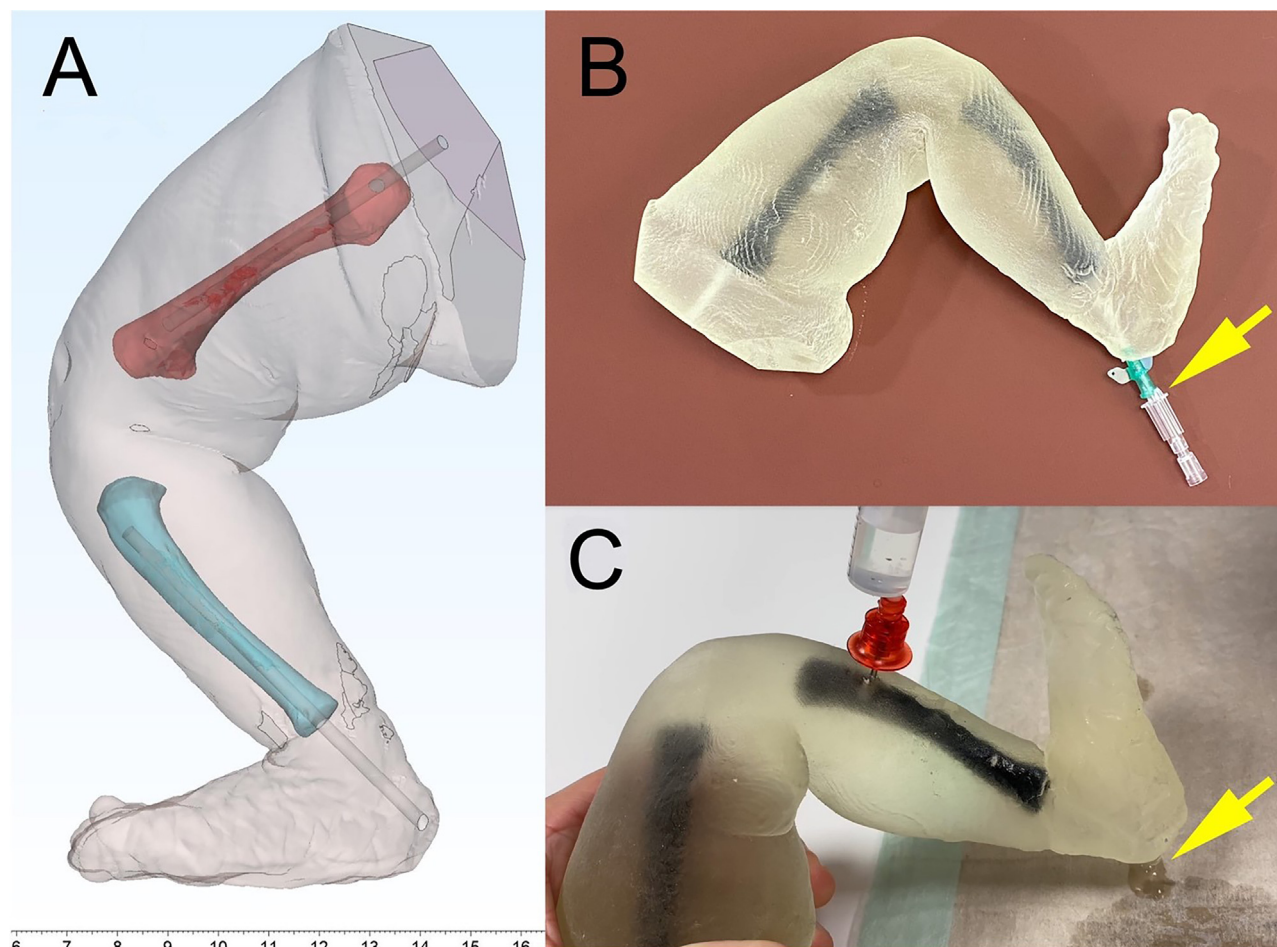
(A) 3D-Model of an infant leg derived from a CT scan of the body of a stillborn infant segmented with the Mimics Innovation Suite® software and generated using the 3-Matic® module. (B) Insertion of an infusion cannula into the monitoring canal of the 3D-printed model demonstrating its patency. (C) Proof of correct placement of the EZ-IO® needle PD 15G into the tibia by flushing it with saline, which exits through the monitoring canal at the heel of the model.
